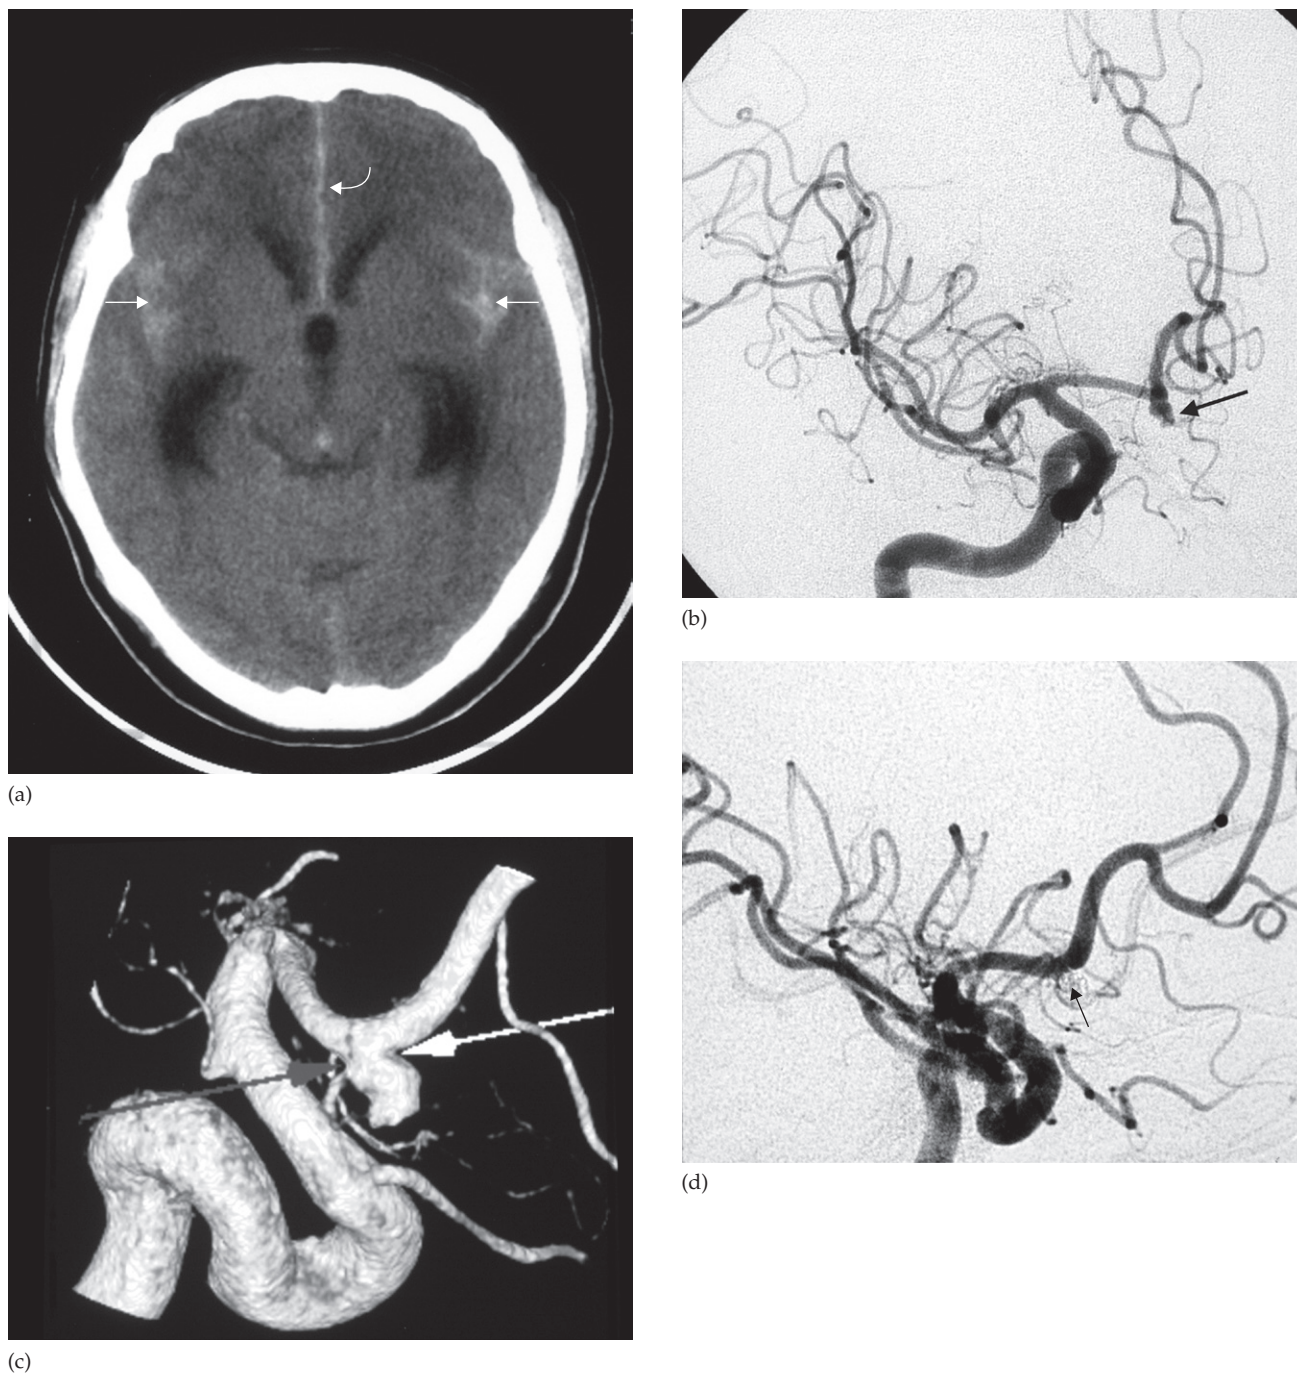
Embolization. (a) CT scan in a patient with a subarachnoid haemorrhage showing high density blood in the Sylvian fissures (arrows) and anterior hemispheric fissure (curved arrow). There is also hydrocephalus. (b) Right internal carotid angiogram showing an anterior communicating artery aneurysm (arrow). (c) The arrows on the three-dimensional formatted image point to the neck of the aneurysm. (d) The aneurysm is obliterated after it is occluded with metal coils (arrow).
